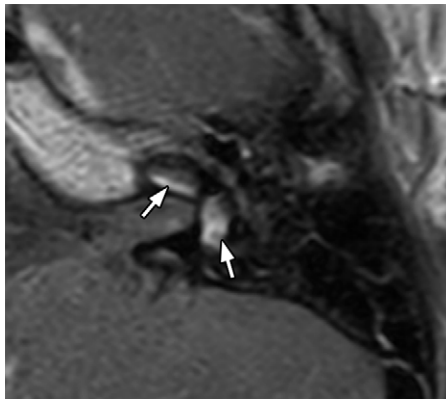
Axial contrast-enhanced T1W FS MR image in a 4-year-old girl with meningitis shows focal enhancement in the cochlear basal turn and vestibule (arrows) consistent with acute labyrinthitis.
